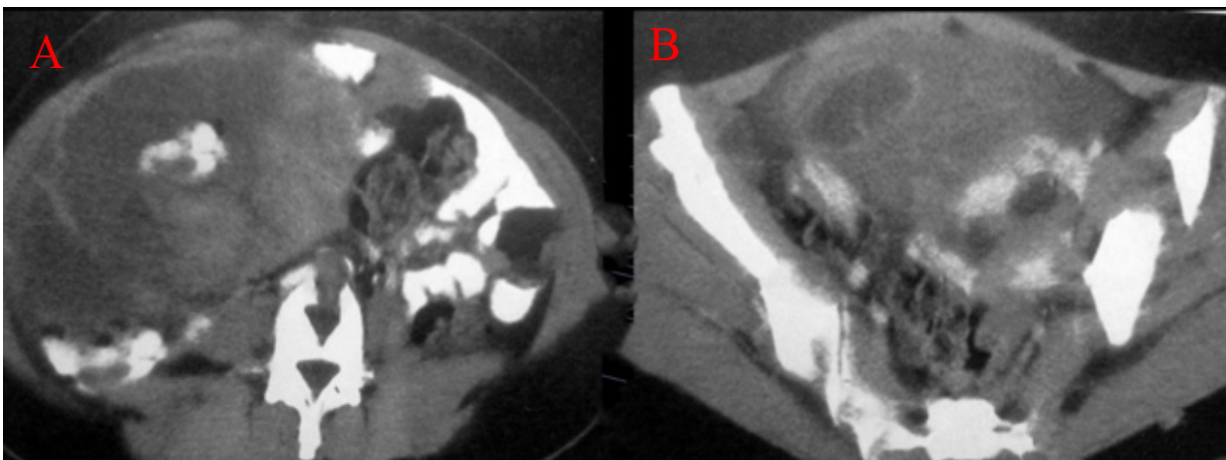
Imaging results of case 3. Red arrow indicates the location of the lump. A, Cystic solid mass in the lower right abdomen. B, CT image of thickened endometrial mass.
